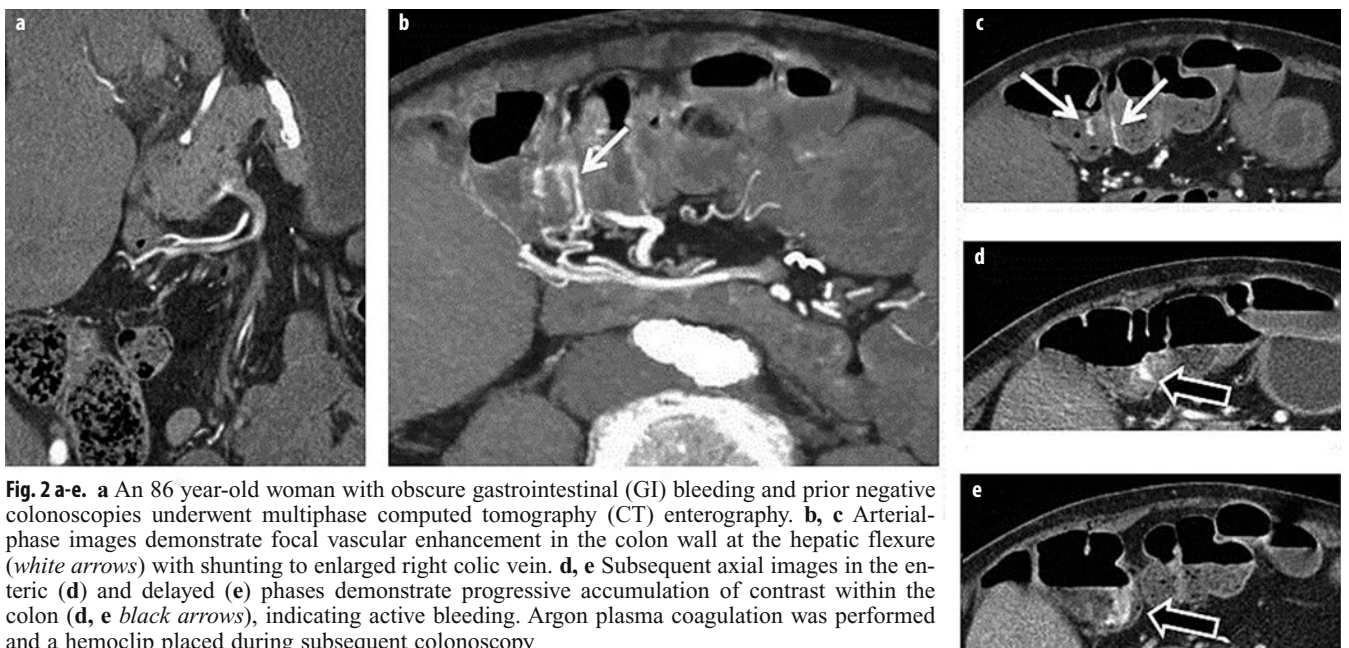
a-e. a An 86 year-old woman with obscure gastrointestinal (GI) bleeding and prior negative colonoscopies underwent multiphase computed tomography (CT) enterography. b, c Arterial-phase images demonstrate focal vascular enhancement in the colon wall at the hepatic flexure (white arrows) with shunting to enlarged right colic vein. d, e Subsequent axial images in the enteric (d) and delayed (e) phases demonstrate progressive accumulation of contrast within the colon (d, e black arrows), indicating active bleeding. Argon plasma coagulation was performed and a hemoclip placed during subsequent colonoscopy
